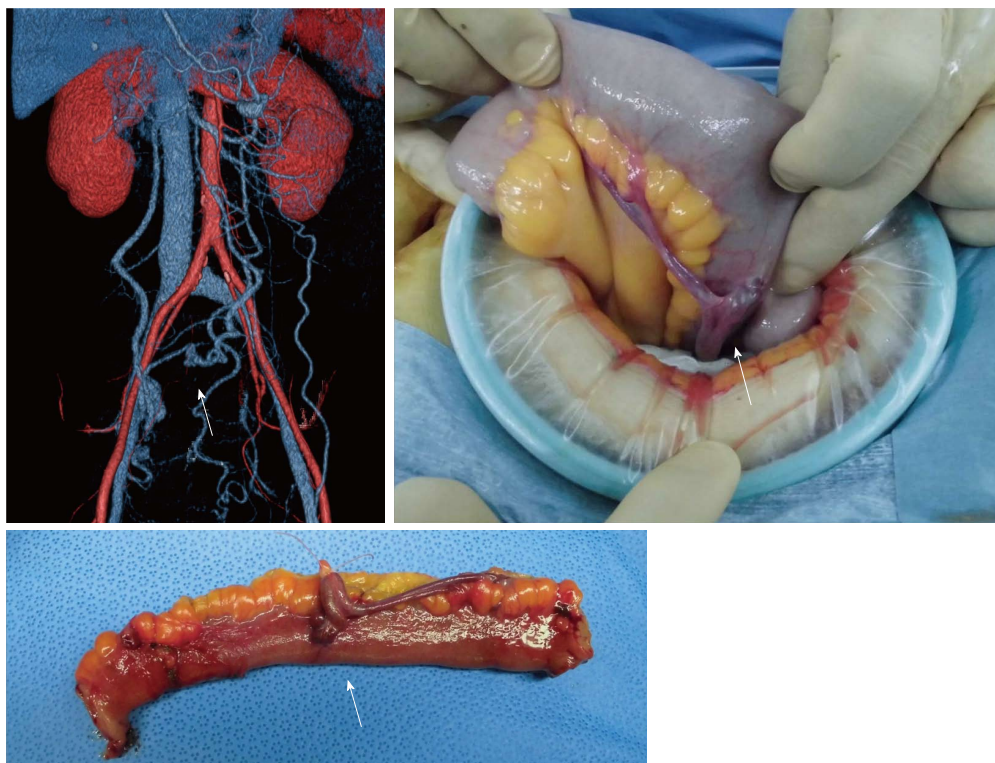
Ileal varices (arrow) were detected using multi-detector row CT and angiography and were resected by laparotomy.
